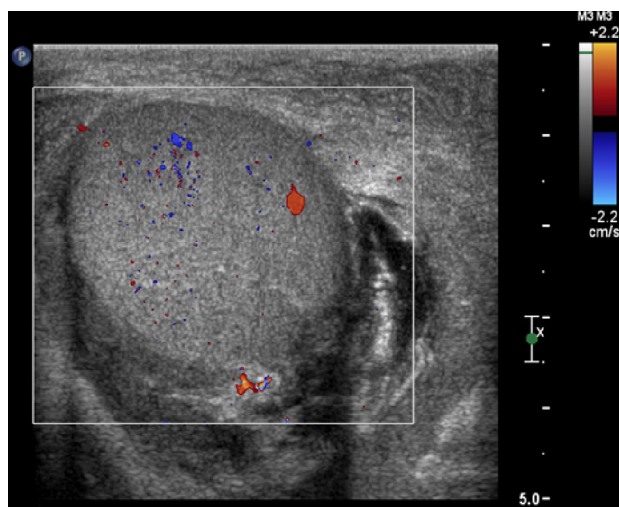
SUS was performed in this patient who sustained a single gunshot wound to the scrotum. Prior to this study, he had undergone a computed tomography that demonstrated findings that were equivocal for left testicular injury. SUS showed appropriate blood flow in the left testis as well as normal contour and echogenicity. Subsequent scrotal exploration was unremarkable for any injuries. SUS, scrotal ultrasonography. (Color version available online.)
